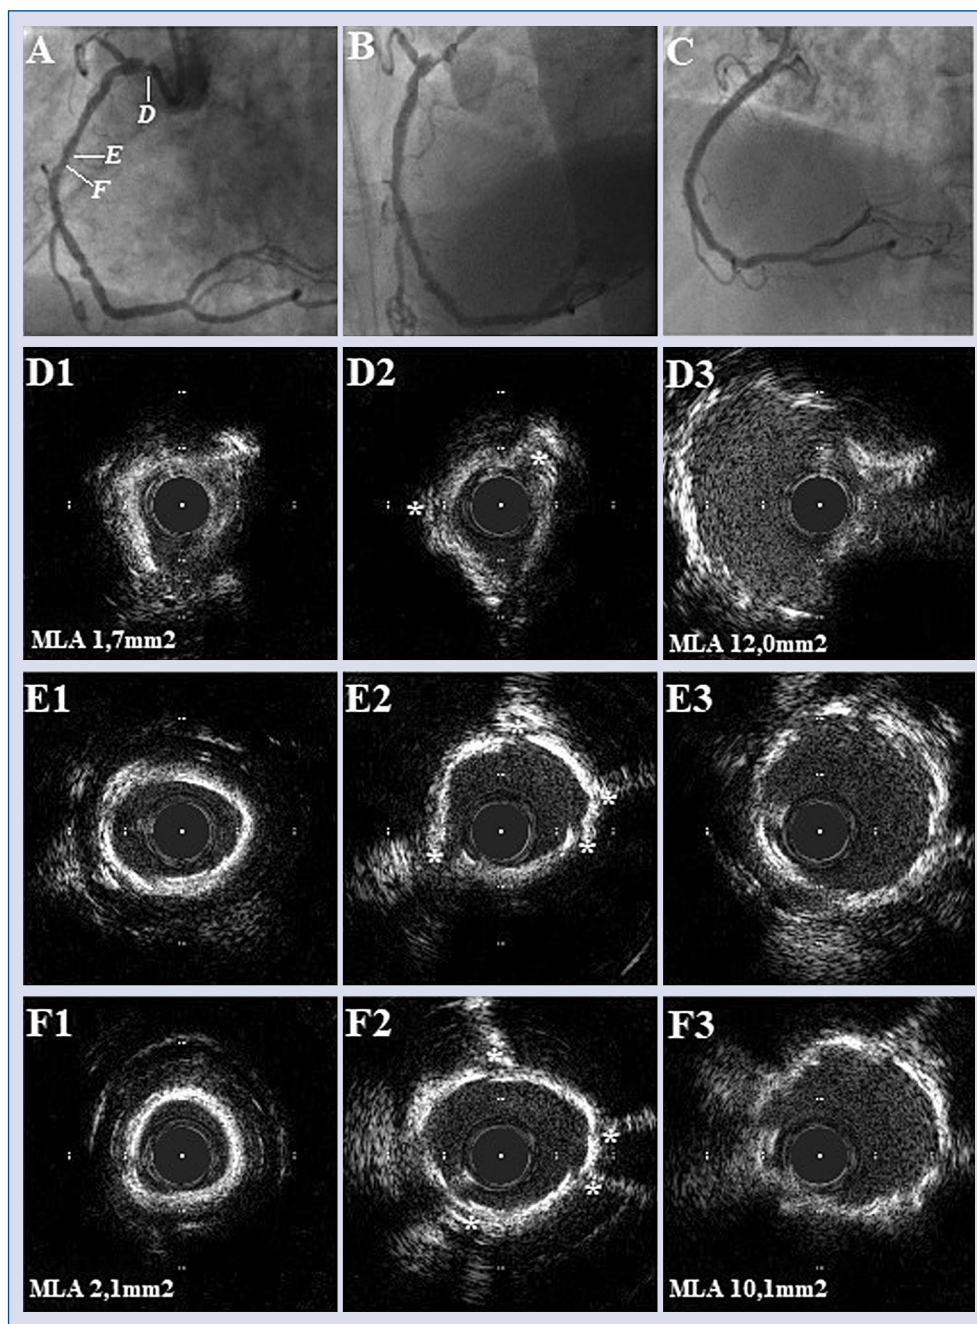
Baseline angiography shows long and diffuse stenosis of the right coronary artery (RCA) involving its aortic ostium (A). Angiography of the RCA after Schockwave balloon modification (B). Final angiographic result after stent implantation (3.0×44 mm distally and 3.5×18 mm proximally) and non-compliant balloons post-dilatation (3.25×12 mm distally and 4.0×12 mm proximally at 24 atm) (C). The intravascular ultrasound (IVUS) images: baseline (D1, E1, F1), after shockwave balloon modification (D2, E2, F2) and final result (D3, E3, F3). Small white lines in Figure 1A point to placement of IVUS images on the RCA angiography, respectively D, E and F. Small white stars (*) in the Figure 1D2–F2 show cracks in calcified plaques with concomitant acoustic shadowings; MLA — minimal lumen area.
